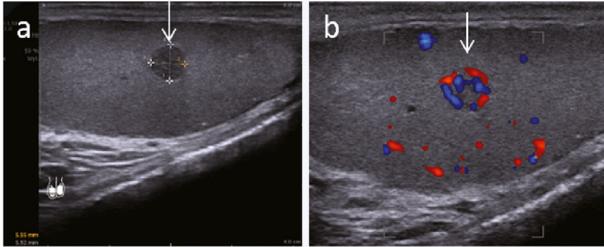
Ultrasound images of incidentally detected seminoma of the testis (*arrows*). (a) B-Mode longitudinal projection reveals a hypo-echoic well-defined lesion. (b) Color Doppler imaging transverse projection reveals increased vascularity of the tumour.
